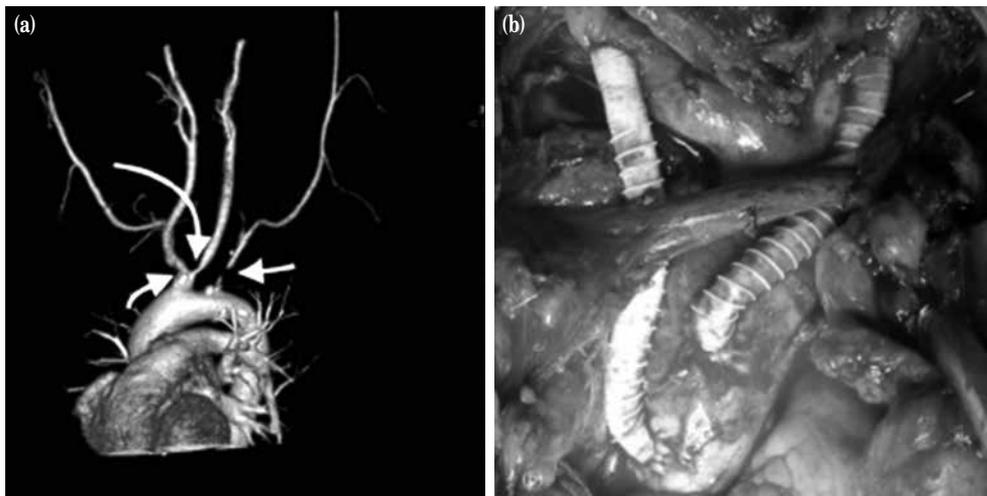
Arrows (inset) showing stenotic areas of the arteries. (a) Computed tomography angiography showing stenosis of supraaortic branches. (b) An intraoperative view of the aorto-bi-carotid bypass graft (Case 1).
